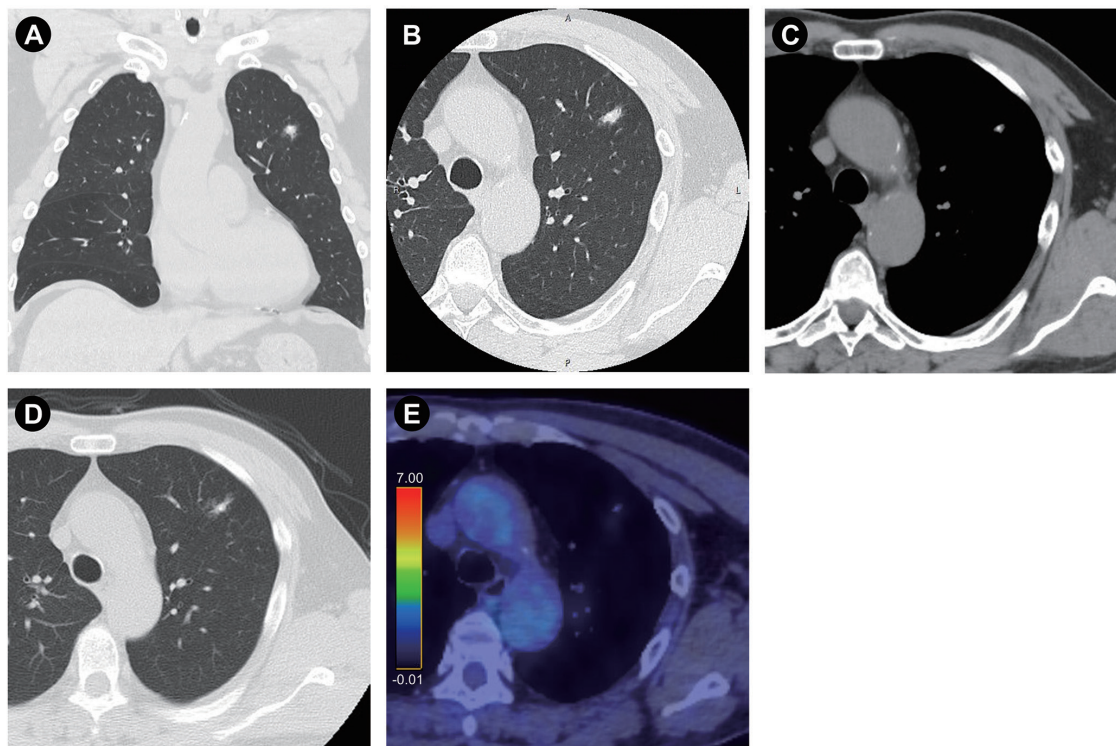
Chest CT images. (A-C) A solitary nodule with calcification in the left upper lobe. (D) An image of the nodule taken at another facility three years earlier. (E) ^{18}F -FDG-PET/CT.
